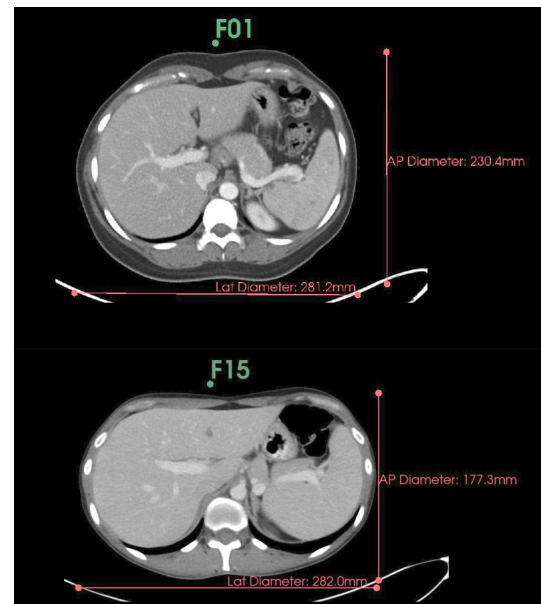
CT image mid liver (axial) of patients F01 - 36.38 BMI and F15 - 16.05 BMI
